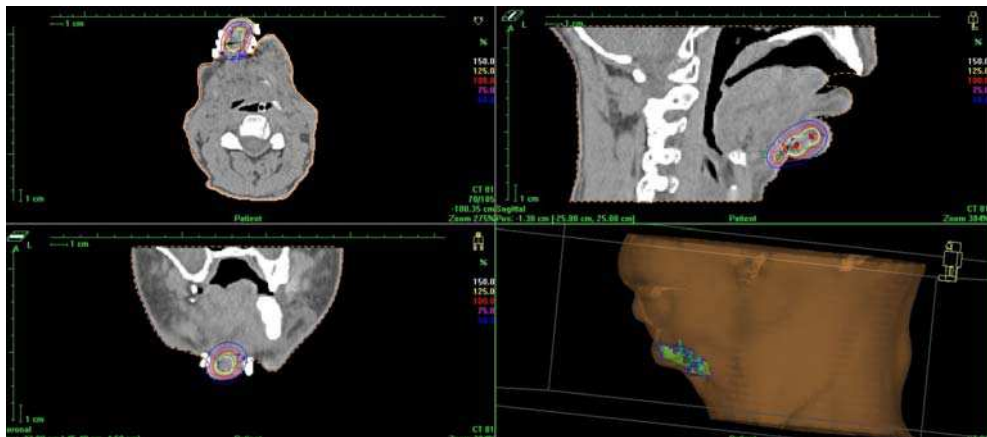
Head and Neck cancer - CT-image based treatment plan. Tumor (recurrence in lymph node system) is located in chin region. (a) Para-transverse image at the level of the tumor, (b) Para-coronal image and (c) Para-sagittal image. On (d) 3D-visualisation of application is presented.
